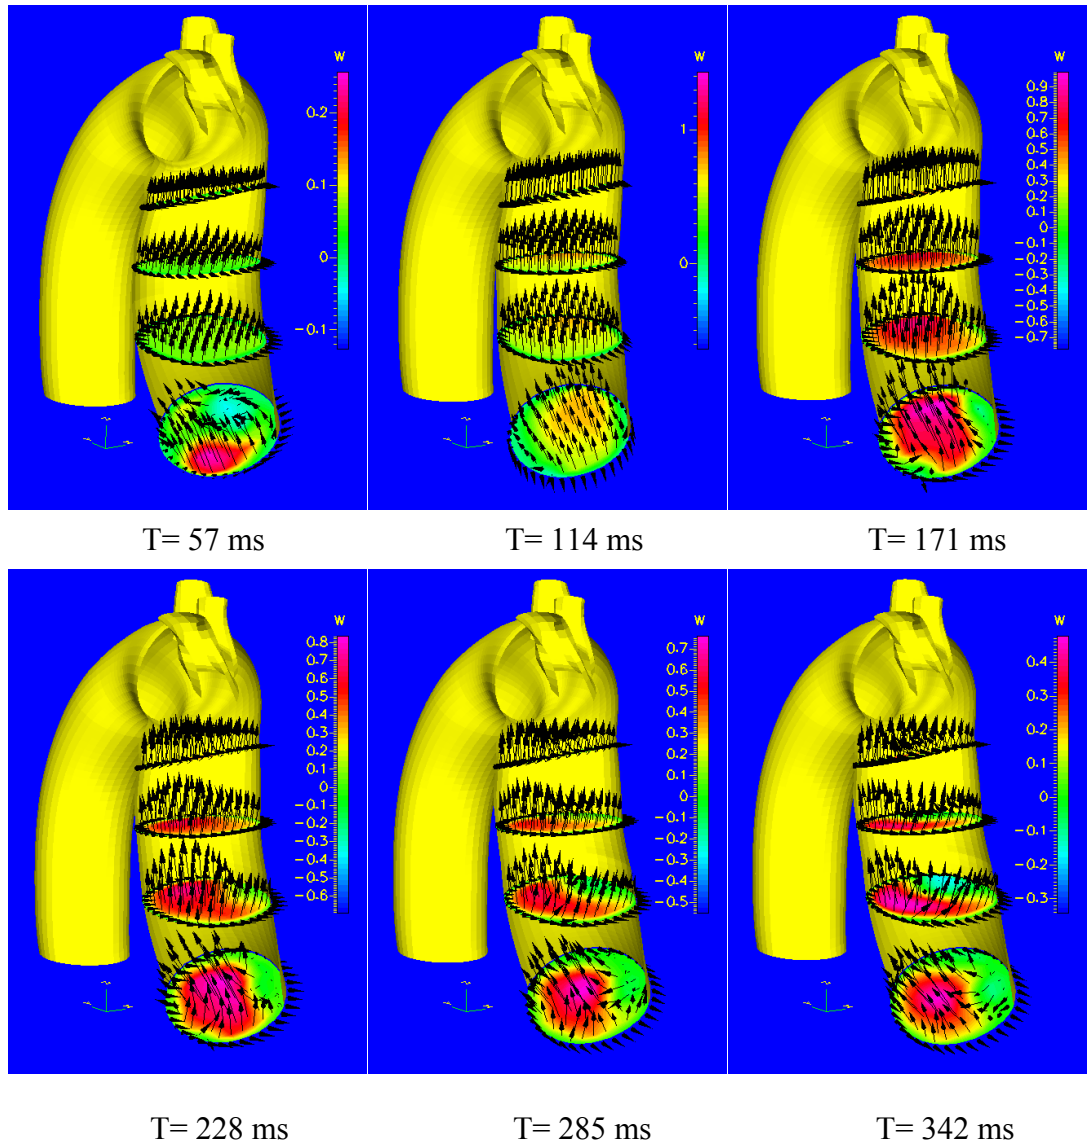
CFD results: velocity vectors and magnitude distributions in the ascending aorta, where the arrows were the 3D velocity vectors and the color map in the sections represented the axial velocity magnitude. The velocity distribution in the inlet section is the PC-MRI results (see Figure 4.2).
